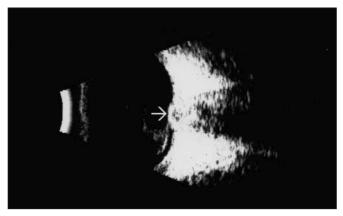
An ultrasound picture of the right eye. A transverse B-scan echogram shows a mildly elevated tumor with a dome-shaped configuration on the optic disc.
